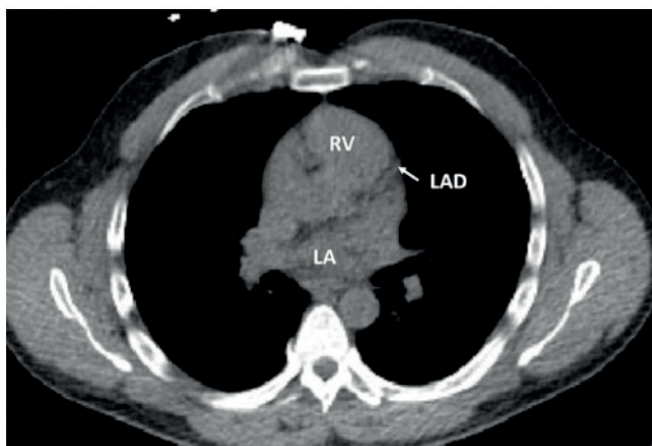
Cross-sectional transaxial chest CT image demonstrating no evidence of coronary artery calcifications [110].
